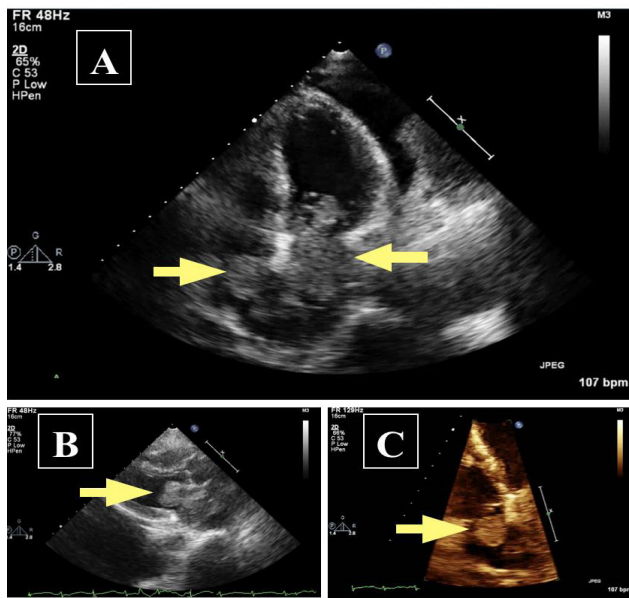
Echocardiography. (A) Four chamber view showing the biatrial mass (yellow arrow) with minimal pericardial effusion without tamponade. (B) PLAX view showing the left atrial mass (yellow arrow) with inferior pole of the mass crossing the mitral valve and prolapsing into the ventricle during diastole causing obstruction of the left ventricular inflow tract. (C) Two chamber view showing the right atrial mass (yellow arrow).
